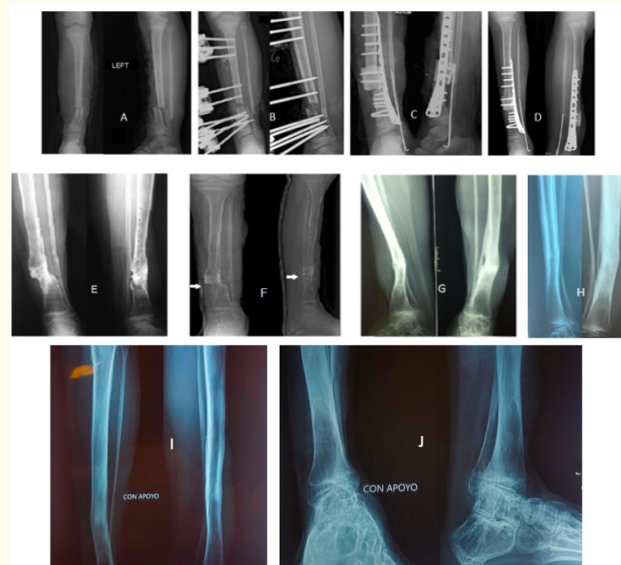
Chronological sequence of bone integration until final remodeling. (A) Initial diagnostic radiograph of the left tibial fracture. (B) Surgical lavage and external fixation of the left tibia showing the bone defect (5 cm). (C) Immediate postoperative X-ray after removal of external fixation and plate osteosynthesis. (D) X-ray 6 months postoperatively showing bone integration. (E) Radiograph after plate and screw removal still showing residual valgus. (F) 12 months postoperatively, the arrow indicates the second fracture below the bone graft site. (G) 24 months postoperatively showing the remodeling of the graft site. (H) 7 years after allograft placement. (I) (J) 7 years after allograft placement.
